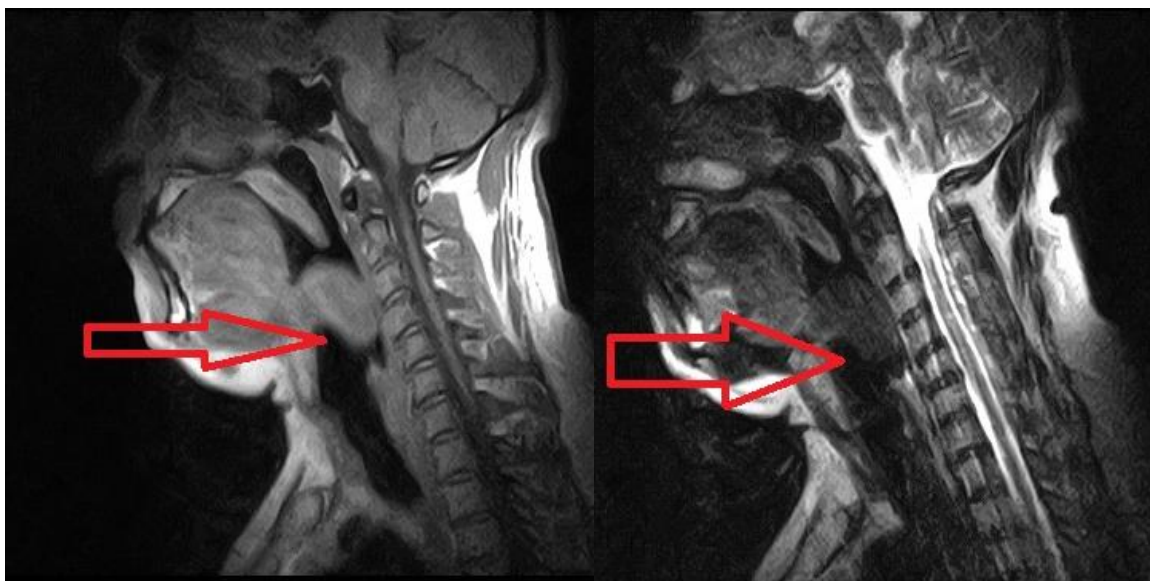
MRI neck sagittal section shows a T1 hypointense and T2 hyperintense ovoid lesion occupying the lower oropharynx and superior aspect of laryngopharynx.
